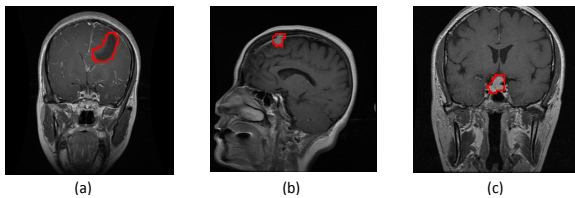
Brain MRI dataset sample of Glioma(a), Meningioma (b), Pituitary tumor (c)
